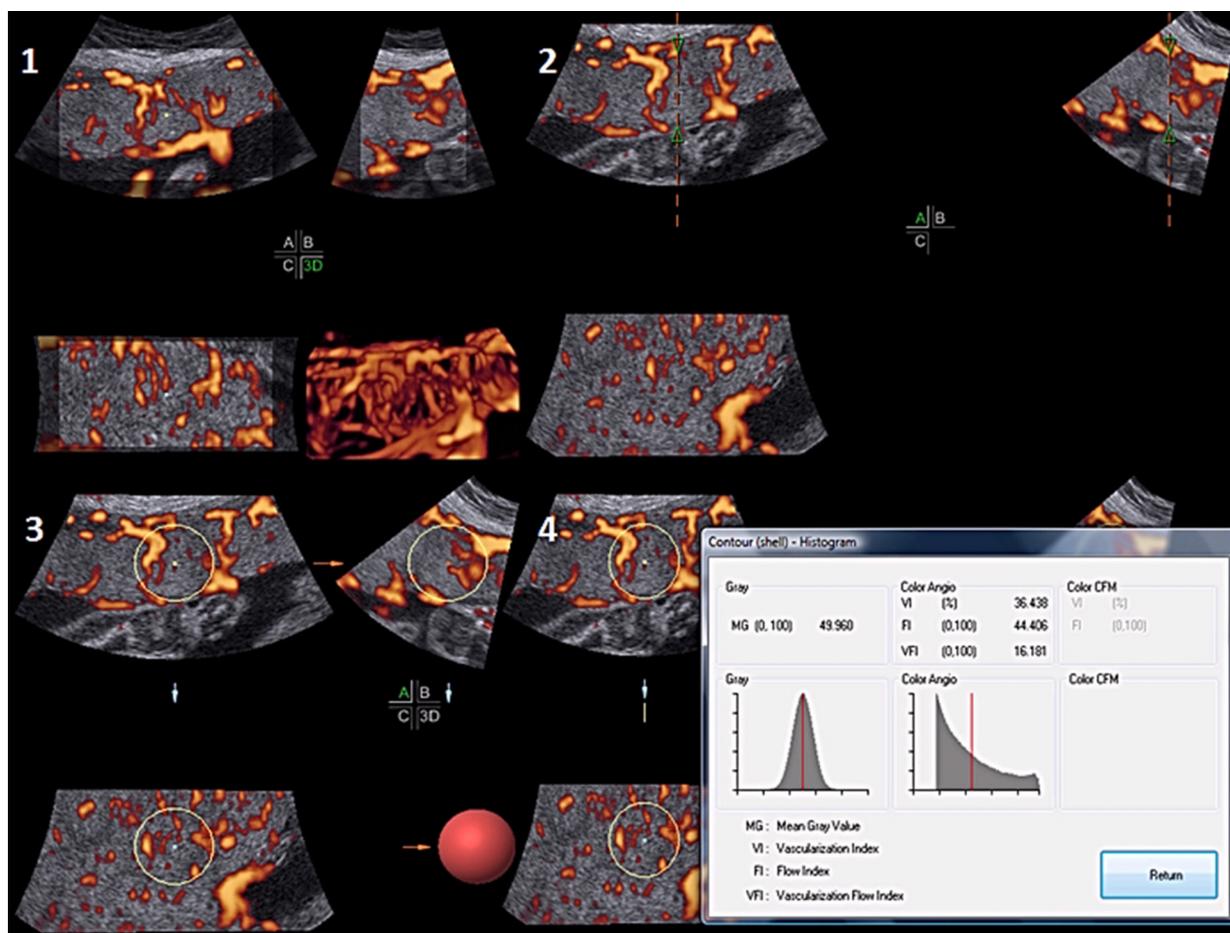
Power Doppler ultrasound of the placenta using the “vascular biopsy” technique. The calipers are positioned at the level of the basal and chorionic plate of the placenta. The software automatically calculates the values of the vascular indices.
